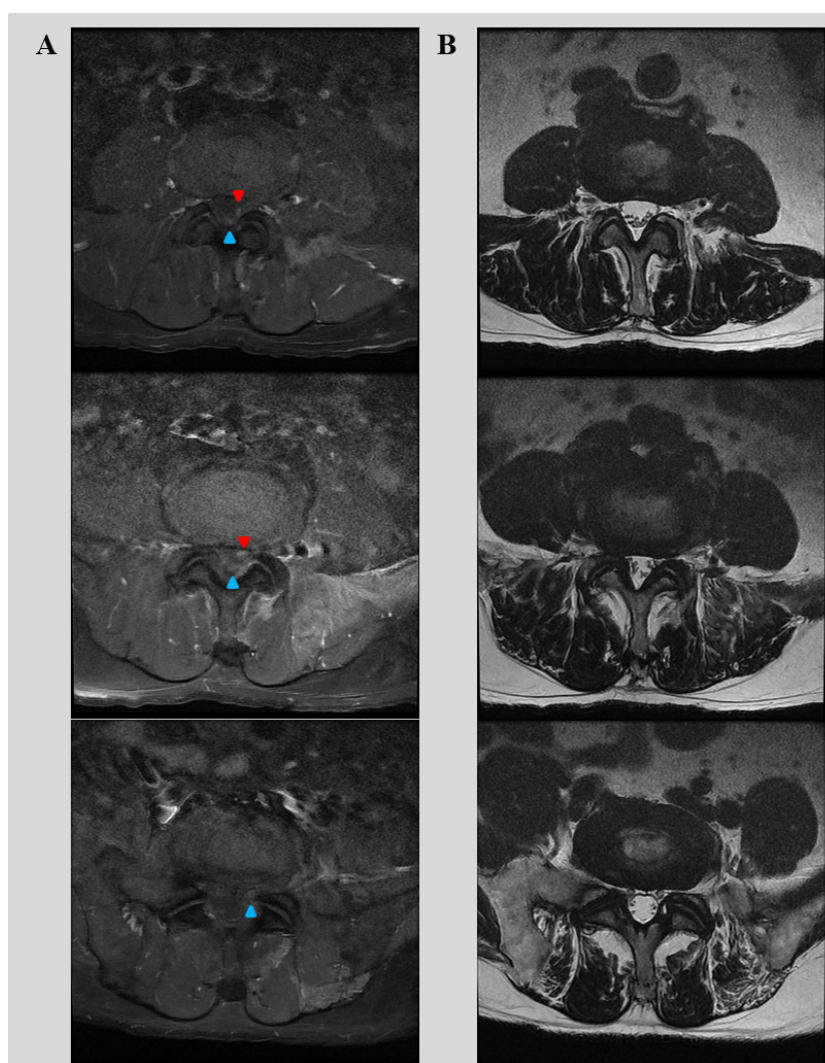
Upper: L3–4 disc space level, middle: L4–5 disc space level, lower L5–S1 disc space level. (A) T1-weighted gadolinium-enhanced axial MRI shows increased intensities in the left L5 and S1 nerve roots (red arrowheads: L5 nerve root; blue arrowheads: S1 nerve root). (B) Conventional T2-weighted MRI shows no abnormal finding in nerve roots.
